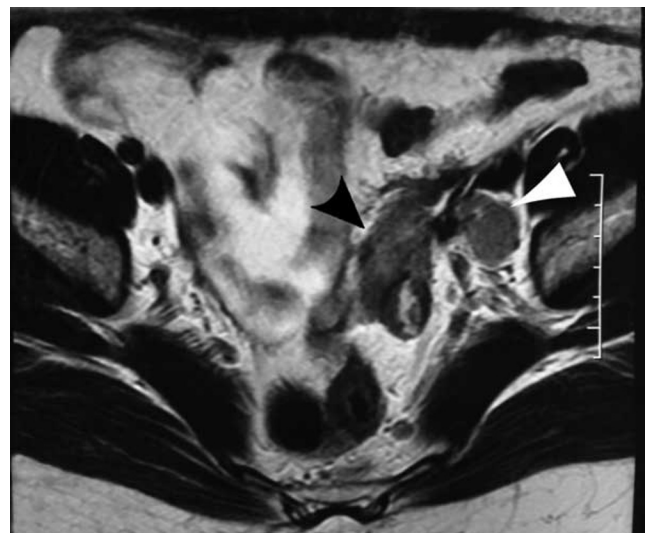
50-year-old woman with ovarian sarcoidosis. T2-weighted MR image of the pelvis depicting left adnexal mass (black arrowhead) concomitant with posteriorly localized complex cystic lesion and enlarged lymph node (white arrowhead) in the left internal iliac chain.
